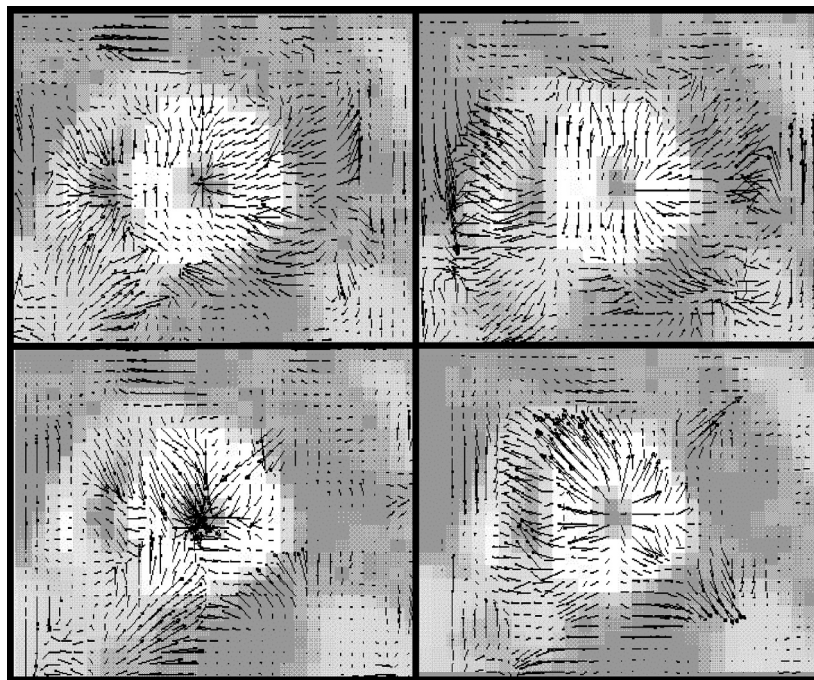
Oblique SPECT slice at systole (left) and diastole (right), superimposed by their velocity vector fields calculated employing the frequency-based approach using WVD (upper row) and CWD (under row).
